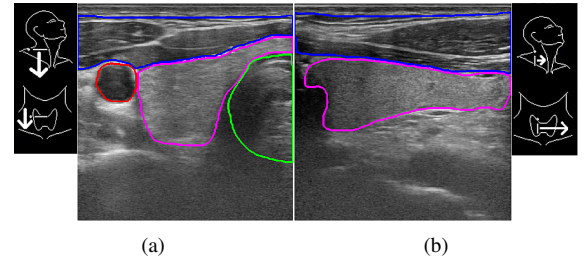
Ultrasound image of the right lobe of the thyroid gland in (a) transverse and (b) longitudinal scans, depicting the boundaries of the thyroid (in purple), the carotid artery (in red), the muscles (in blue) and the trachea (in green) that have been manually delineated by a trained sonographer.
